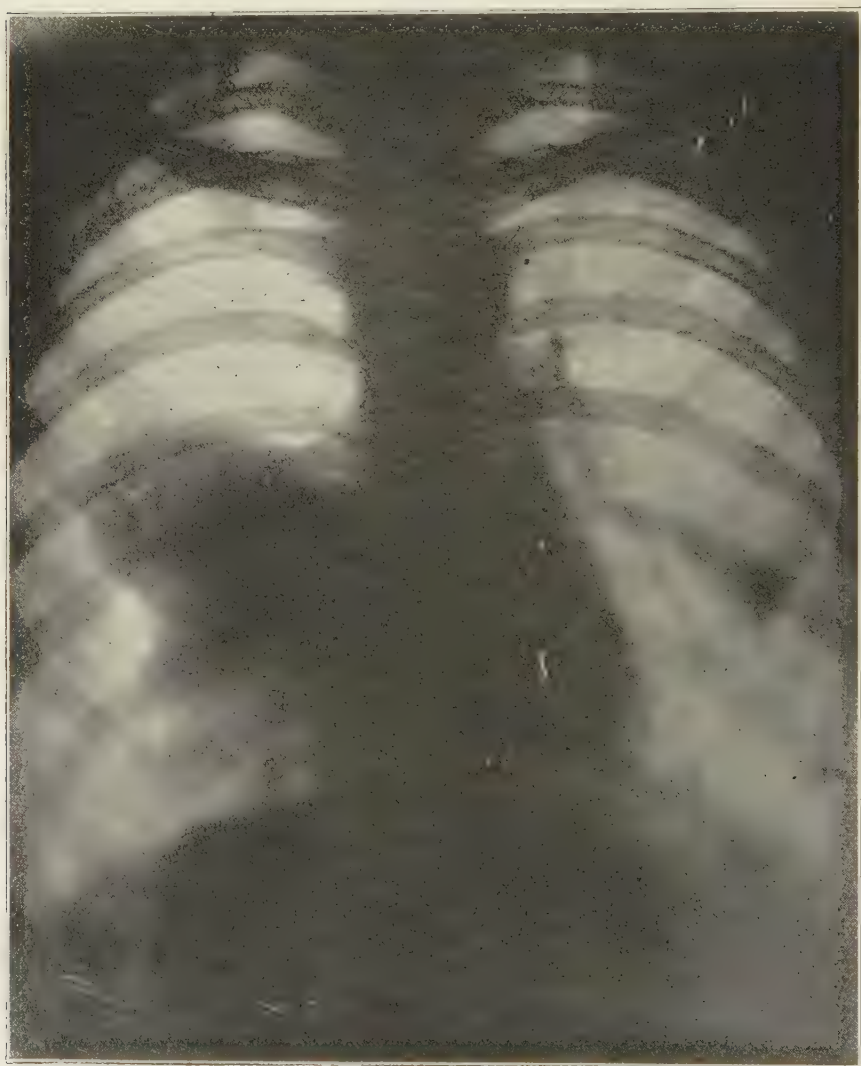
Radiograph of same case as in Fig. 55, after collapse of lung.
